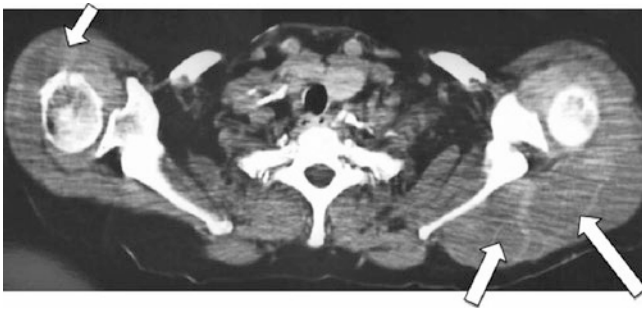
CT scan of the shoulder showing periarticular infiltration (shoulder pad sign)
